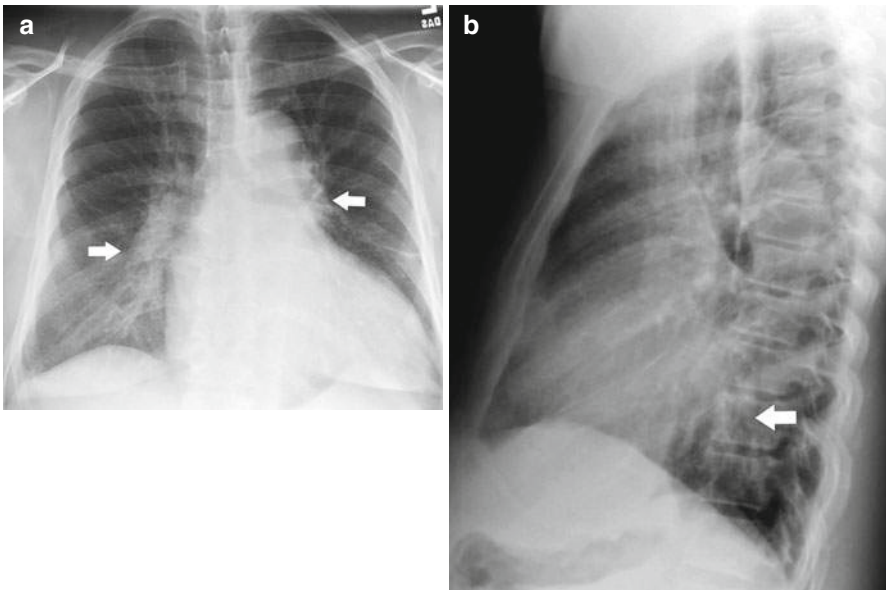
Congestive heart failure. Chest X-ray posteroanterior (a) and lateral (b) views show bilaterally enlarged pulmonary vessels (arrows) and cardiac enlargement
